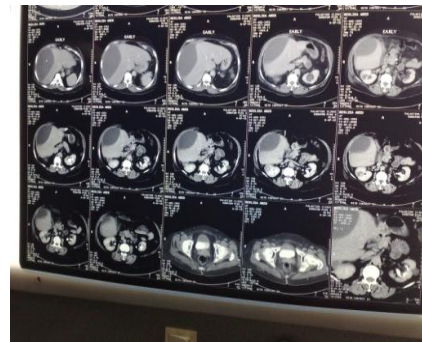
Collection as seen by CT scanning
